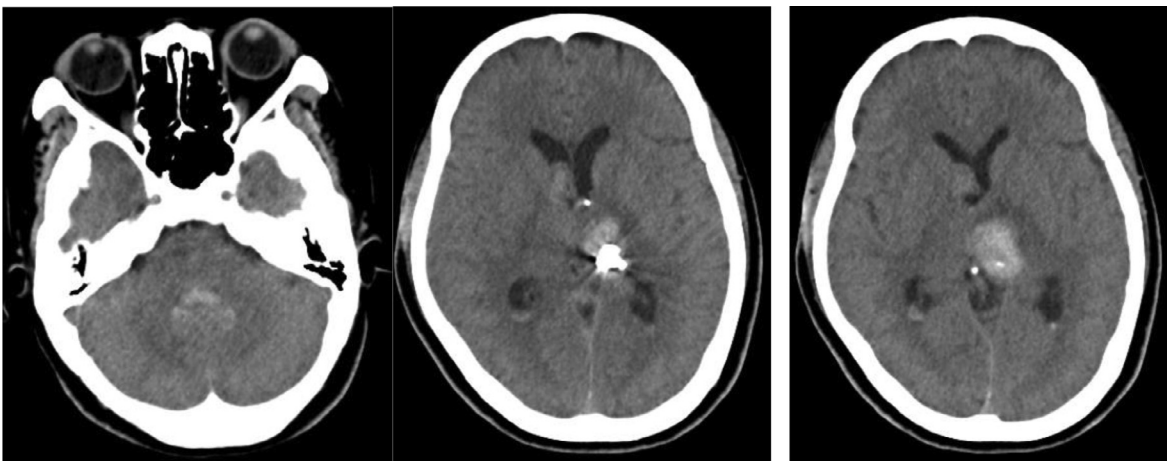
CT scan of the brain after 5 days of intervention showed decreased blood volume in the left thalamus and blood in the lateral and fourth ventricles was almost completely dissolved.
